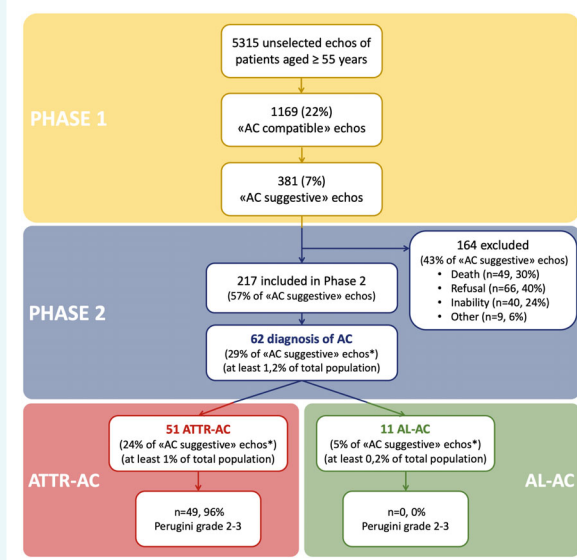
Flow-chart showing amyloid cardiomyopathy (AC) prevalence. Summary of Phase 1 (upper panel) and Phase 2 (middle and bottom panels) of the AC-TIVE study. 'AC compatible' echos, echocardiograms with (i) interventricular septum thickness ≥ 12 mm in women and ≥ 13 mm in men, (ii) left ventricular ejection fraction $\geq 50\%$, and (iii) indexed left ventricular end-diastolic volume ≤ 85 ml/m²; 'AC suggestive' echos, 'CA compatible' echocardiograms plus at least one of the following echocardiographic red flags: (i) restrictive filling pattern (E-wave deceleration time <120 ms or ≤ 150 ms in presence of $E/A \geq 2$) and/or increased left ventricular diastolic filling pressures ($E/E' \geq 15$), (ii) granular sparkling appearance of the myocardium, (iii) pericardial effusion of any entity, (iv) interatrial septum thickness >5 mm; (v) atrio-ventricular valve thickness >5 mm, and (vi) left ventricular apical sparing pattern at speckle tracking echocardiography. *The percentage is calculated among the 217 patients who completed Phase 2; however, the substantial comparability of basal characteristics and red flag distribution allowed to generalize the results to the entire cohort of patients with 'AC suggestive' echocardiograms. AL, light chain amyloid; ATTR, transthyretin amyloid.
